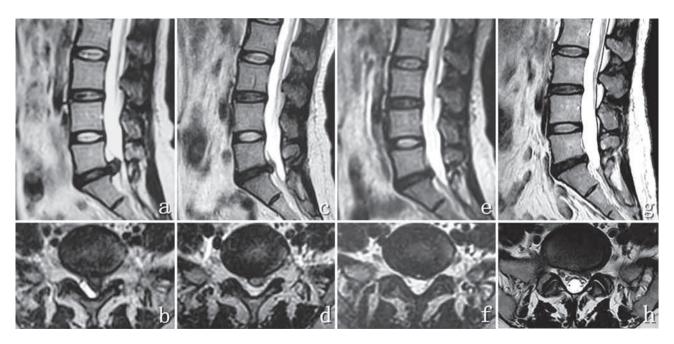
MRI scan of a 51-year-old female : left hernia L5S1, 1693.02 mm<sup>3</sup>. Important resorption down to 781.55 mm<sup>3</sup> over a 20 month period.
